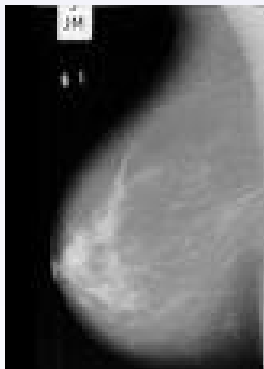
Classical detection methods in mammography (II): x-rays
